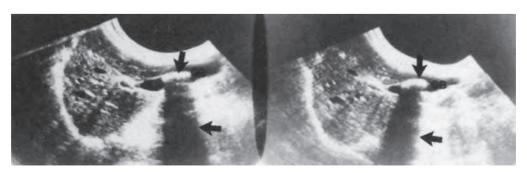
Ultrasound examination demonstrating a large gallstone (vertical arrow) with the associated acoustic shadows (transverse arrow) which are characteristic of gallstones. GB, gallbladder.
